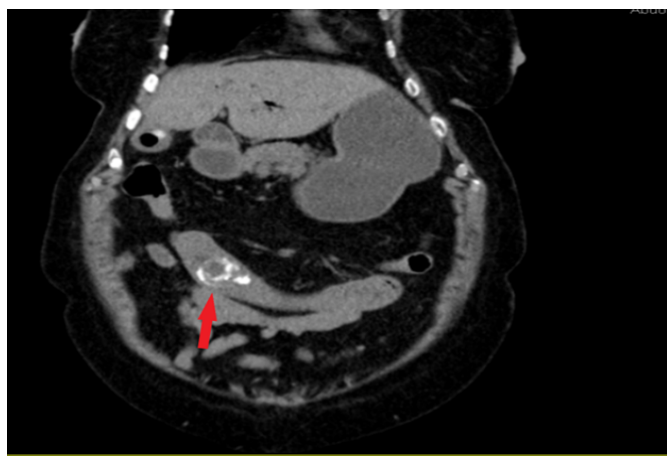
Abdominal CT without contrast - biliary ileus
